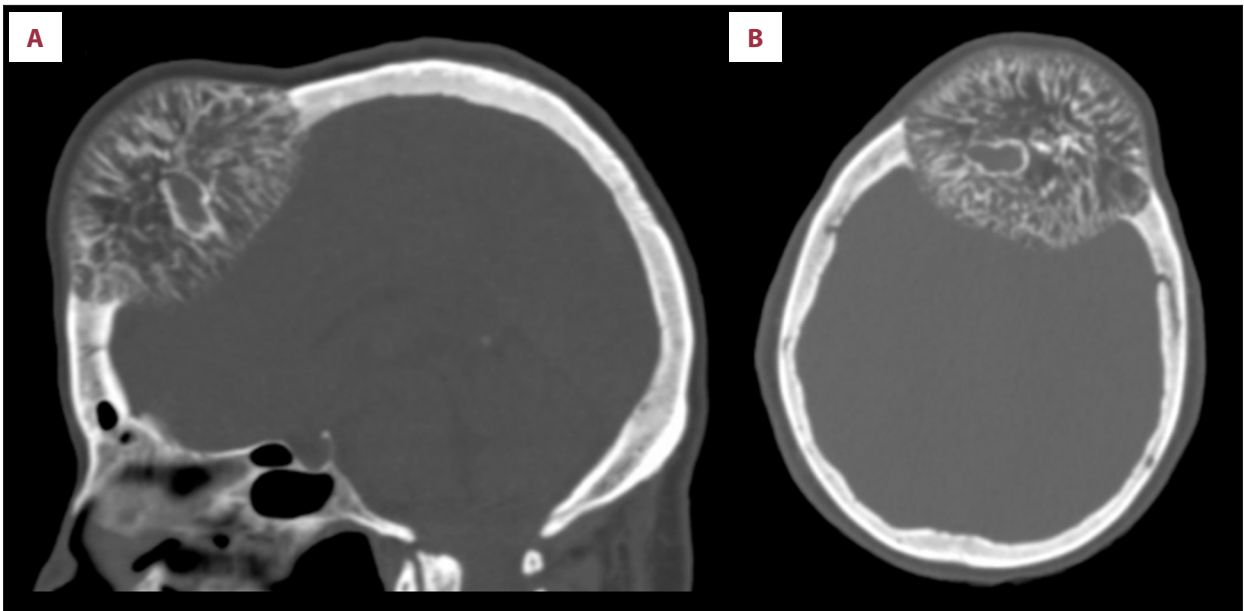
Sagittal (A) and axial (B) bone window CT images show a sharply margined, expansile lesion arising from the frontal skull with a sunburst pattern of trabecular thickening radiating from a common center. Note the associated expansion of the inner and outer tables of the frontal skull.
